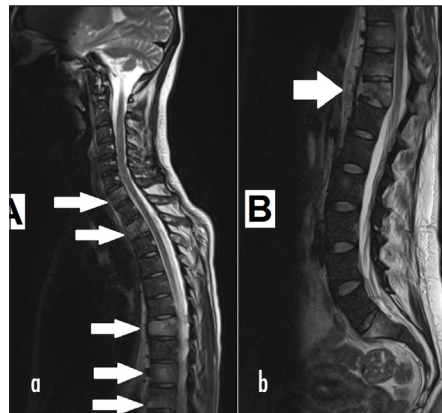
Magnetic resonance images of the (a) cervical and (b) thoracic spine showing lytic lesions (solid arrows) in a number of vertebrae.
